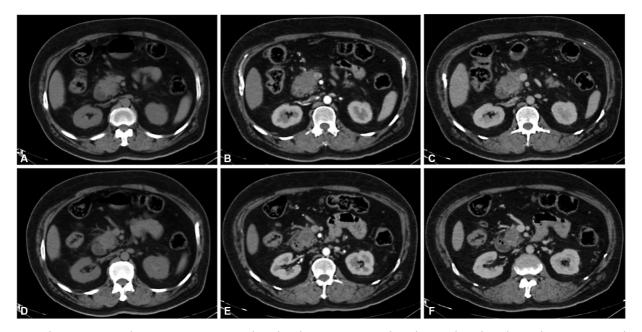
Axial CT images A, D-plain, B, E-pancreatic parenchymal, and C, F-portovenous phase depicts a hypodense hypoenhancing mass involving the head of the pancreas. Radiologically, this represents a resectable pancreatic carcinoma.
